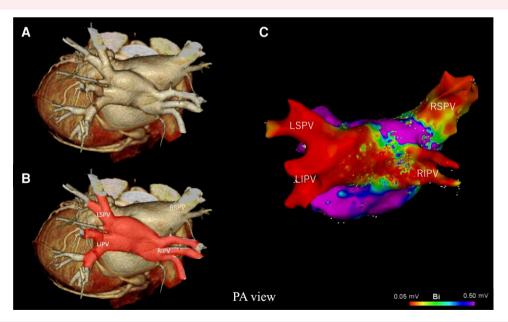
(A and B) Pre-procedural cardiac computed tomography demonstrating right inferior pulmonary vein, left inferior pulmonary vein, and left superior pulmonary vein have one common trunk. (C) Left atrium voltage map before ablation obtained during pacing from the right atrium shows that the common pulmonary veins were low voltage area bounded by the common trunk entrance.
